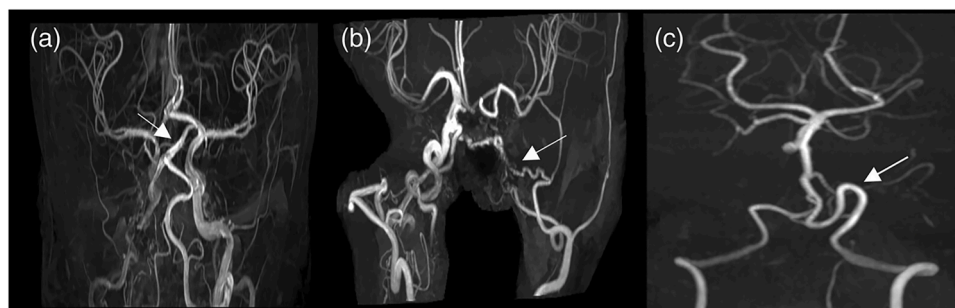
Magnetic resonance imaging and maximum intensity projection time-of-flight magnetic resonance angiography showing arterial abnormalities seen in patients with PHACE syndrome. (a) Persistence of primitive vessels (arrow). (b) Diffuse narrowing (arrow). (c) Vessel tortuosity, with kinking of vertebral artery (arrow). Adapted with permission from Hausman-Kedem et al., 2023.
